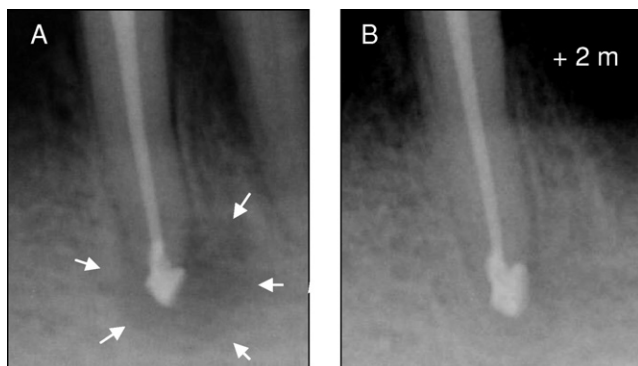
Healing of a periapical lesion after the Apexum procedure. (A) The immediately postoperative radiograph; note accidental major extrusion of the obturation material, a single case of its type in the whole study. Arrows indicate the extent of the periapical lesion. (B) A follow-up radiograph at 2 months.
